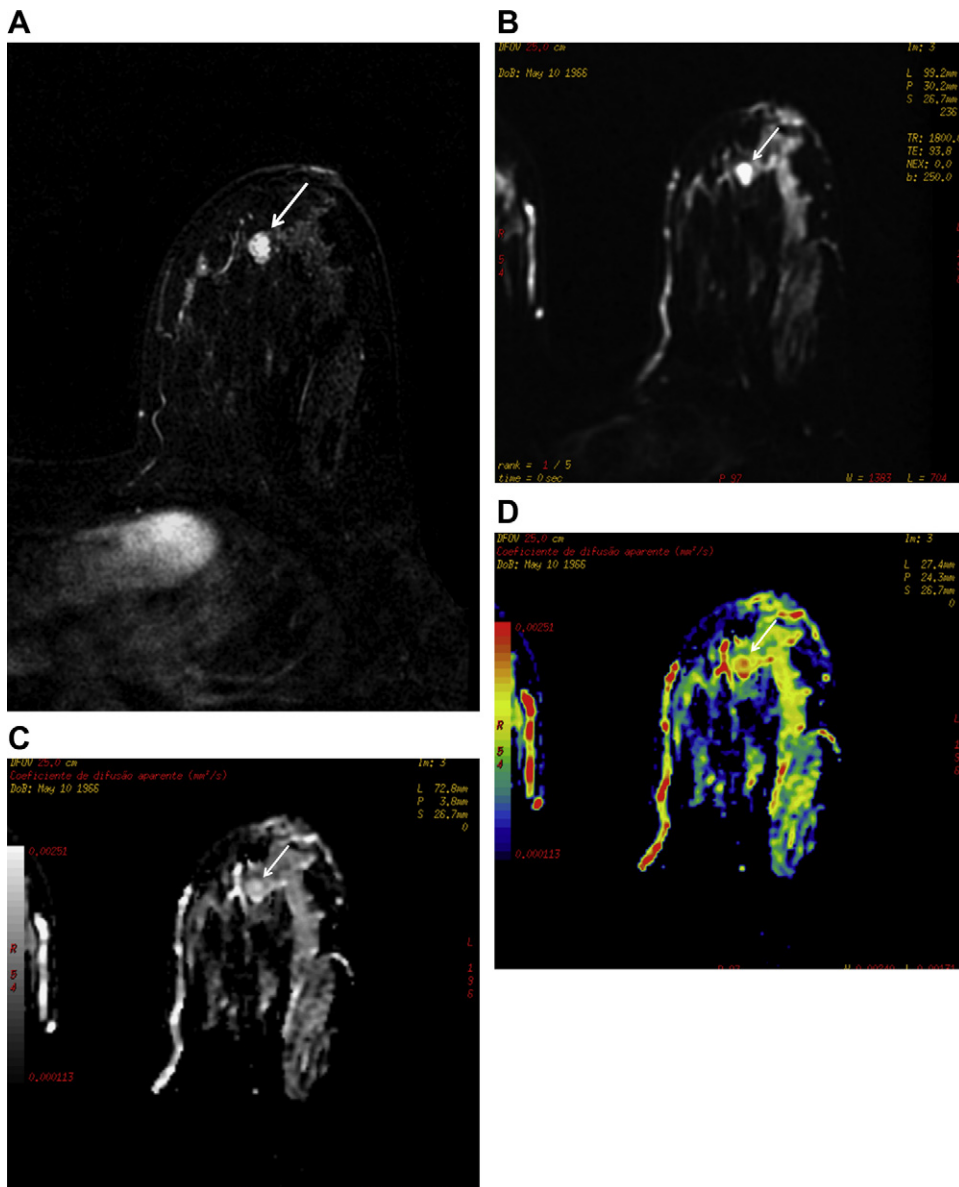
43-year-old woman with fibroadenoma of the left breast. (A) Axial contrast-enhanced T1-weighted three-dimensional spoiled gradient-echo image, first phase, subjected to subtraction technique. (B) Axial diffusion-weighted image. (C) Axial black-and-white and (D) colored ADC maps obtained using b-values of 0 and 750 s/mm^2 reveal a 1.3-cm mass (white arrows) classified as suspicious by conventional MR imaging. Note the high signal on the ADC black-and-white map and the red on the ADC colored map, which suggest that the lesion is benign.
